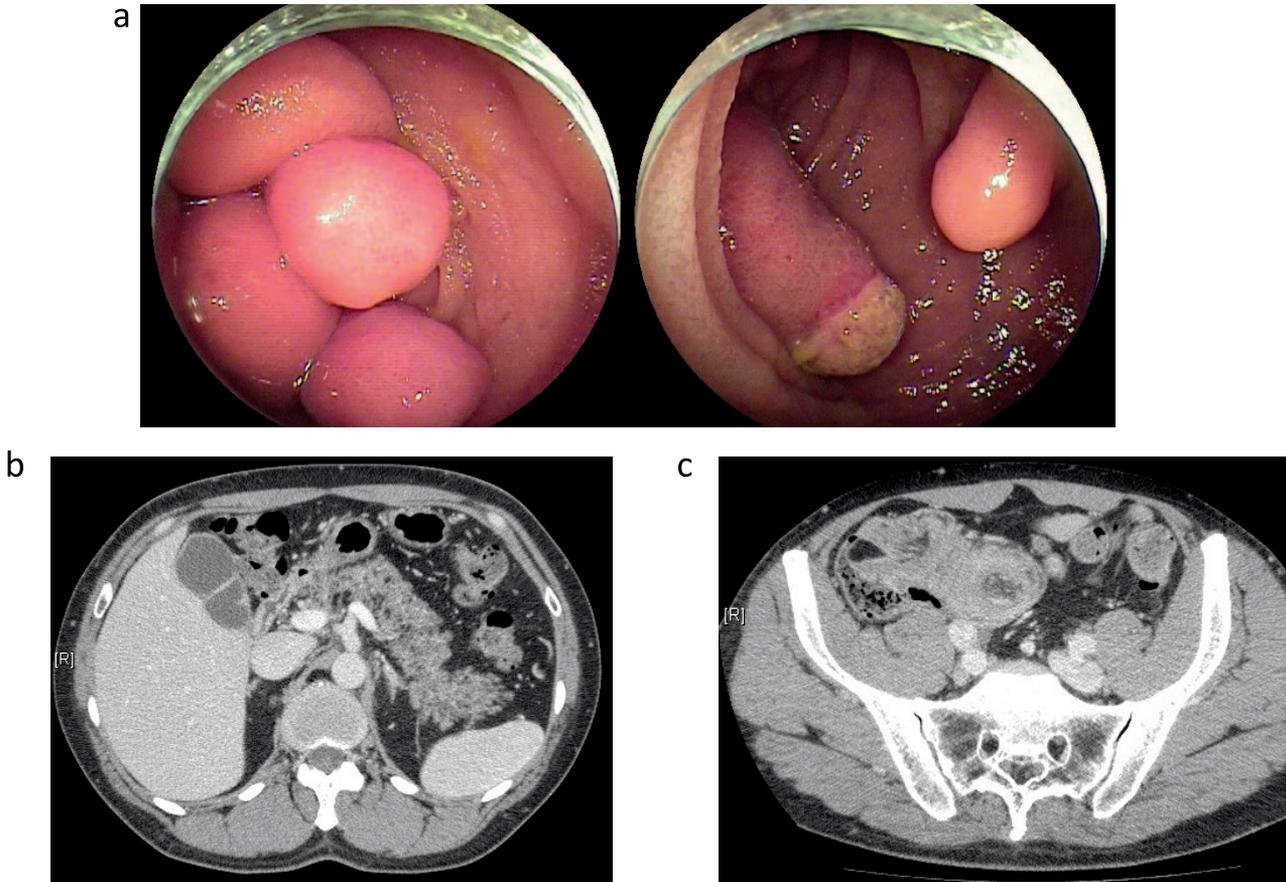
Clinical findings from endoscopy and CT before the first surgery. (a) Enteroscopy before the first surgery shows multiple soft, yellowish masses with mucosal erosion. (b) Pancreatic fat infiltration is evident. (c) Concentric sign suggesting ileocecal intussusception due to leading lipoma.
